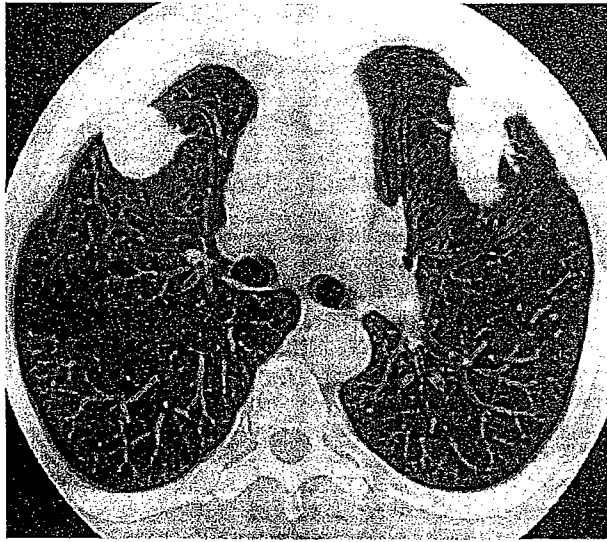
Bilateral Round Atelectasis. A 10-mm collimation CT scan in a 58-year-old patient demonstrates bilateral round atelectasis. Vessels and bronchi can be seen sweeping around and into the focal area of atelectasis. There is evidence of volume loss with anterior displacement of the right upper lobe bronchi. The bilateral areas of atelectasis abut calcified pleural plaques. (Courtesy of Dr. Louise Samson, Hotel Dieu de Montréal, Quebec.)
